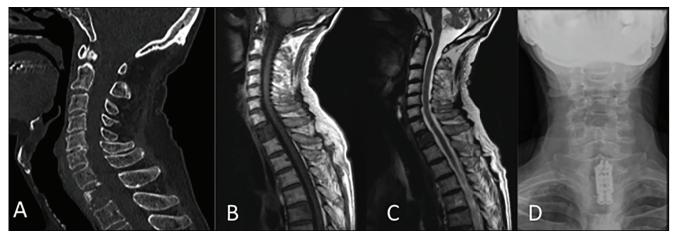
Radiologic images from Case 12, a patient with neuroendocrine origin metastatic disease with T1 vertebral body compromise: (a) Sagittal CT; (b and c) T1- and T2-weighted magnetic resonance imaging; (d) anteroposterior radiograph of reconstruction
